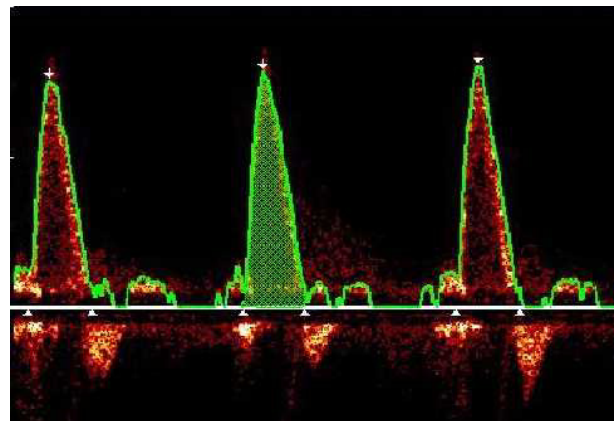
The velocity-time Doppler waveform
